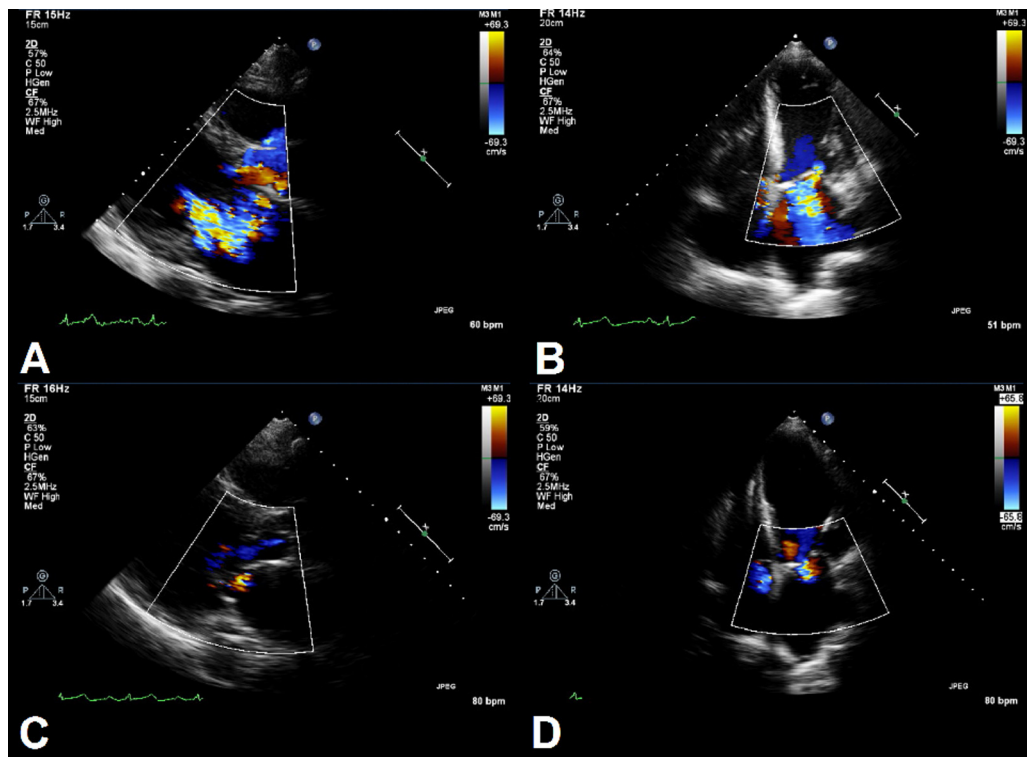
(A) The parasternal long-axis view (B) and apical four-chamber view, transthoracic echocardiography showed severe left ventricular systolic dysfunction and functional mitral regurgitation. No organic change in mitral leaflet and/or mitral tendon rupture was found. (C and D) Functional mitral regurgitation dramatically improved with right-atrium-only pacing at 80 bpm.
